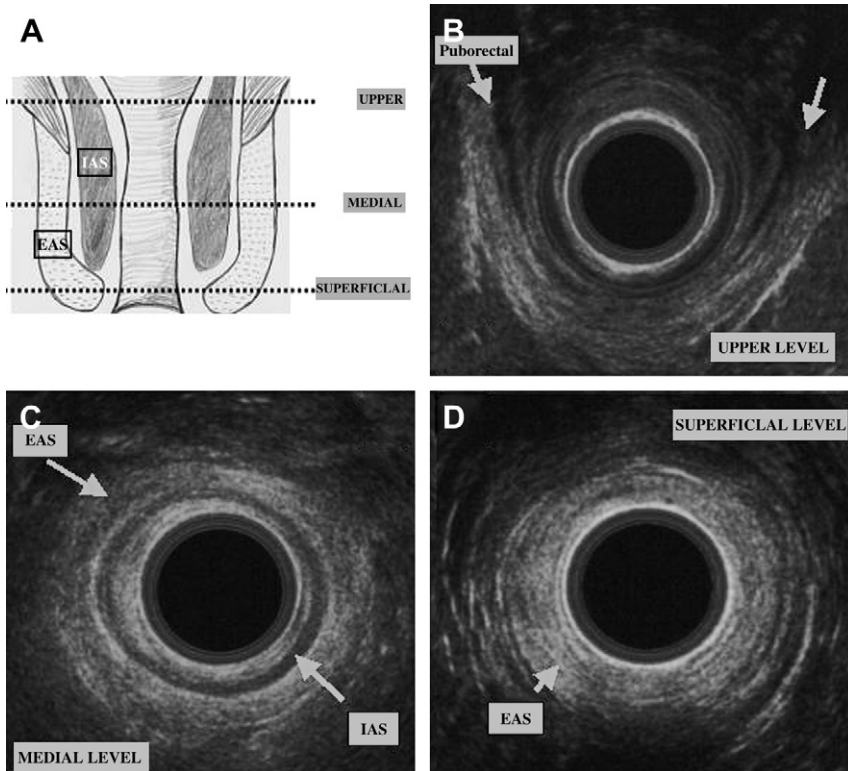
Anal endosonography. (A) The anal canal in the coronal plane showing the internal (IAS) and external (EAS) anal sphincters. The three following different levels of anal endosonography (B–D) are shown (dotted lines). (B) Upper level showing the “U-shaped” puborectal muscle (arrows). (C) Medial level showing both the EAS (superior arrow) and IAS (inferior arrow). (D) Superficial level showing the EAS alone (arrow).
